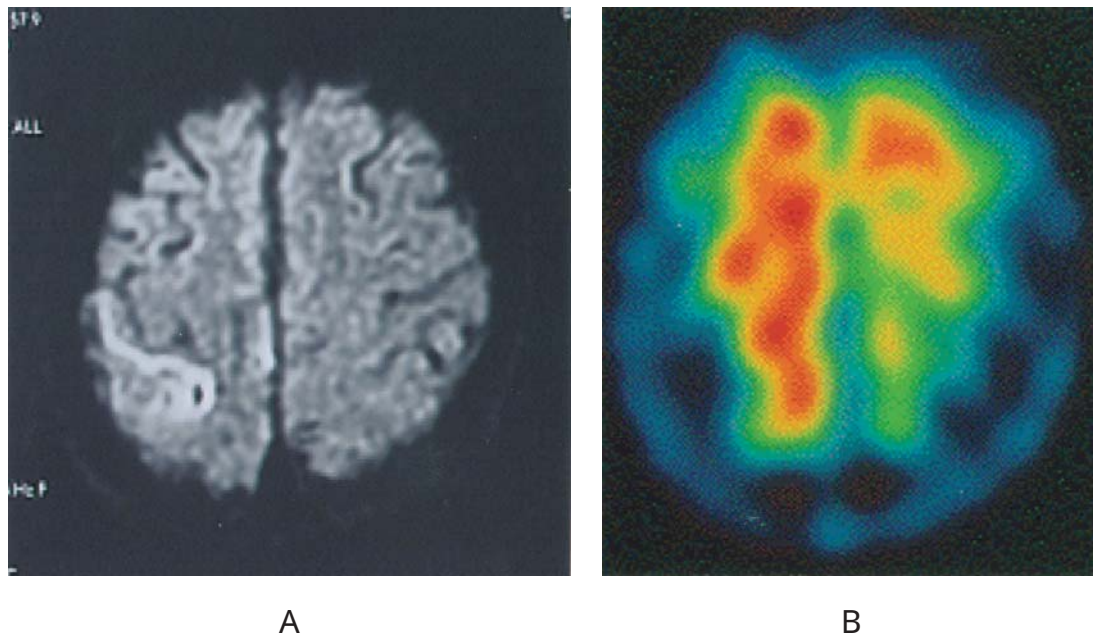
A) MR diffusion-weighted image showing an epileptogenic focus at the post central gyrus on admission in November 2000. B) Tc-99m HMPAO brain SPECT in January 2001.
